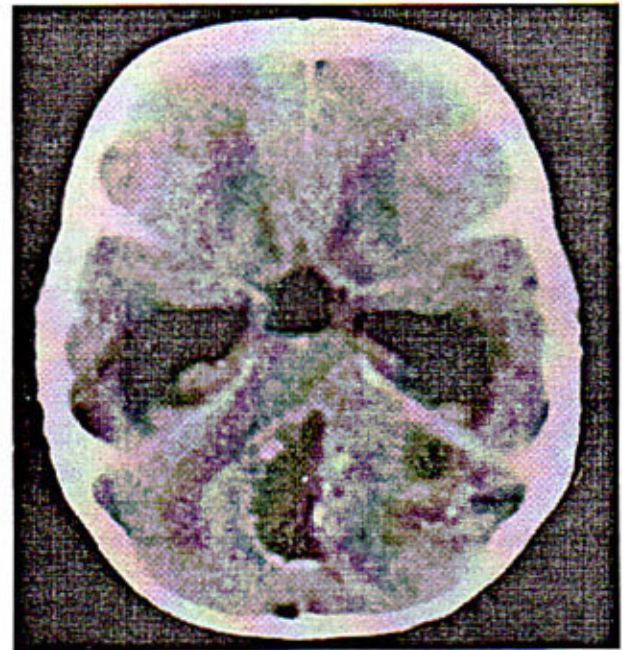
Contrast enhanced CT Scan.
